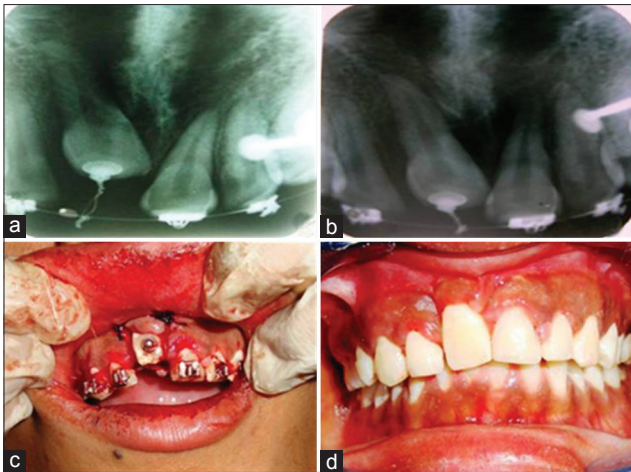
(a) Three months follow-up radiograph. (b) Six months follow-up radiograph. (c) Apically positioned flap raised at 6 months to maintain adequate width of the attached gingiva. (d) Right maxillary permanent central incisor in occlusion
